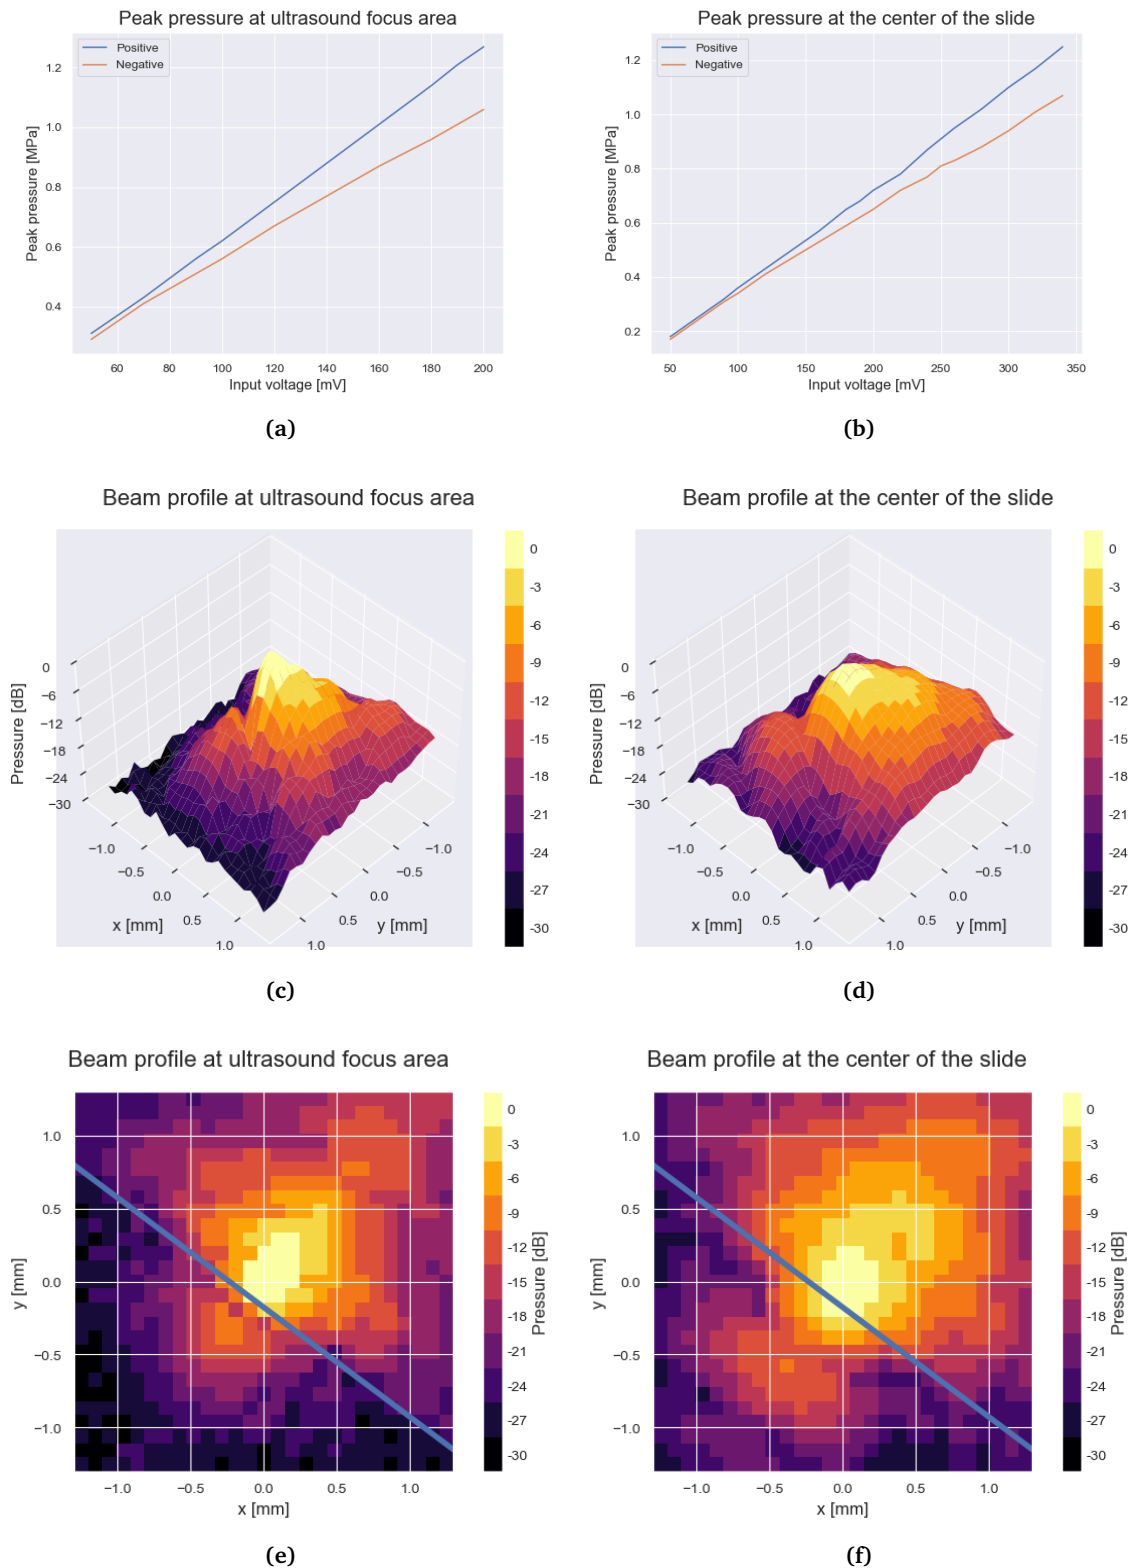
Characterization of the ultrasound transport measurement setup at two different distances, 73.5 and 80.0 mm away from the transducer diaphragm. This represents the focus area of the transducer, and the center of the sample slide which is in the far-field of the ultrasound beam. Figures a and b show the relationship between input voltage to the power amplifier and peak positive and negative pressure. Figures c and d show 3D surface plots of the ultrasound pressure related to position, and figures e and d show the same information as filled contour plots. The area to the bottom left of the blue line in plot e and d is where the beam from the ultrasound transducer is blocked off.
